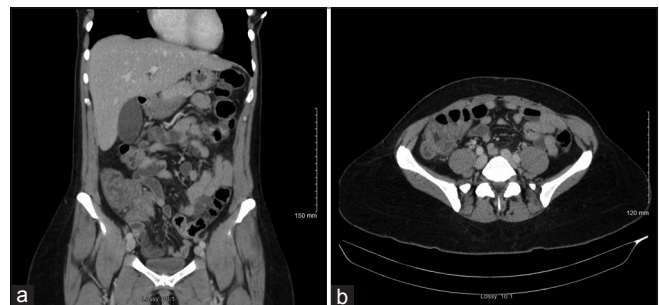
Axial section of CT scan of abdomen with intravenous contrast showing wall thickening of cecum with adjacent mild inflammatory stranding
